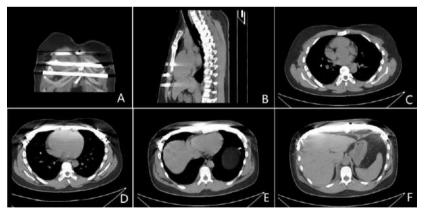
CT examination of chest wall after operation. A, The coronal plane shows the position of the three bars; B, The sagittal plane shows the position of three bars; C, The cross-sectional view of the chest wall above the plate; D, E, F, The cross-sectional plane shows the positions of three steel bars.
